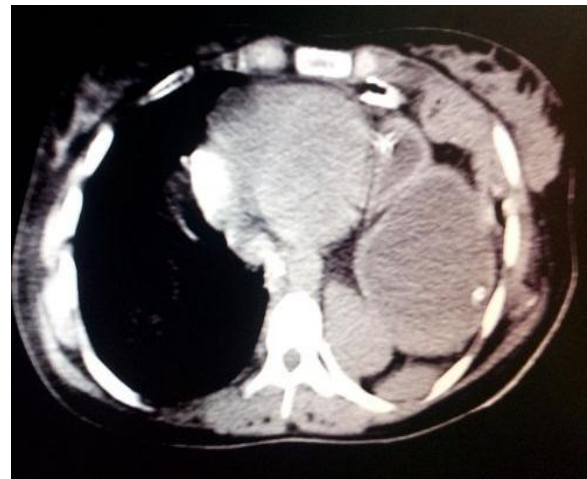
3- Plain CT chest showing stomach with Ryle's tube and bowel loops in the left hemithorax.
